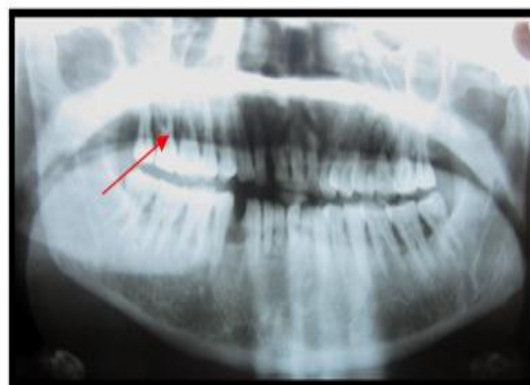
Orthopantomograph shows severe generalized bone loss extending from 13 to 18.
